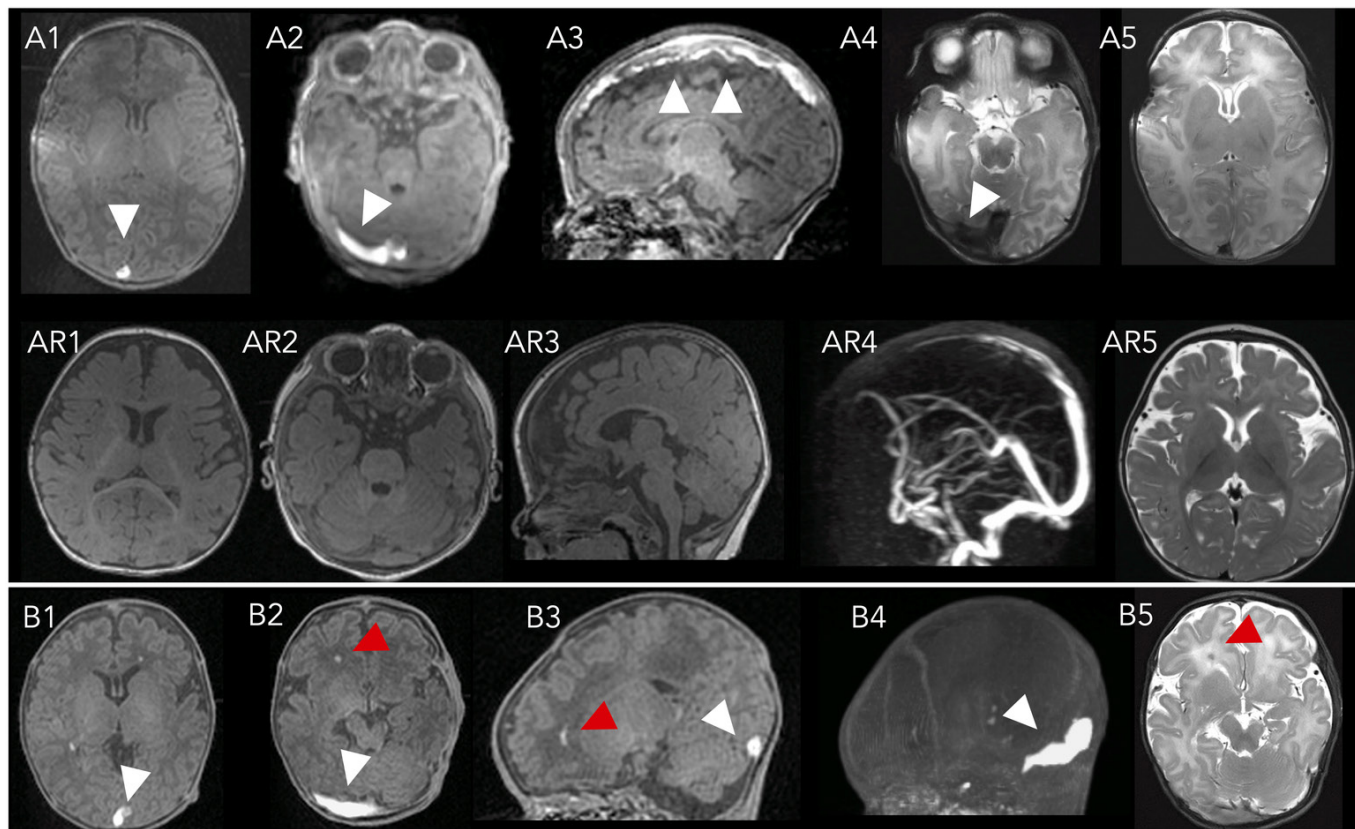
Neonate A: T1-weighted axial (A1, A2) and sagittal (A3) images and T2-weighted (A4, A5) axial MRIs of the brain at 10 days of age in a term infant with moderate HIE who received erythropoietin. White arrows indicate extensive thrombosis in sagittal sinus, right transverse sinus and cortical veins. Repeat MRI at 6 months showed normal T1-weighted axial (AR1, AR2) and sagittal MR scans (AR3), MR venography (AR4) and T2-weighted axial scan (AR5). Neonate B: T1-weighted axial (B1, B2) and sagittal (B3) and maximal intensity projection (B4) and T2-weighted axial (B5) MRIs of the brain at 20 days of age in a term infant with moderate HIE who received erythropoietin. White arrows denote expansion with T1 shortening and loss of the normal flow void at the level of the transverse sinuses (right greater than left) and inferior aspect of the torcula. Red arrows indicate punctate white matter injury. HIE, hypoxic ischaemic encephalopathy.
